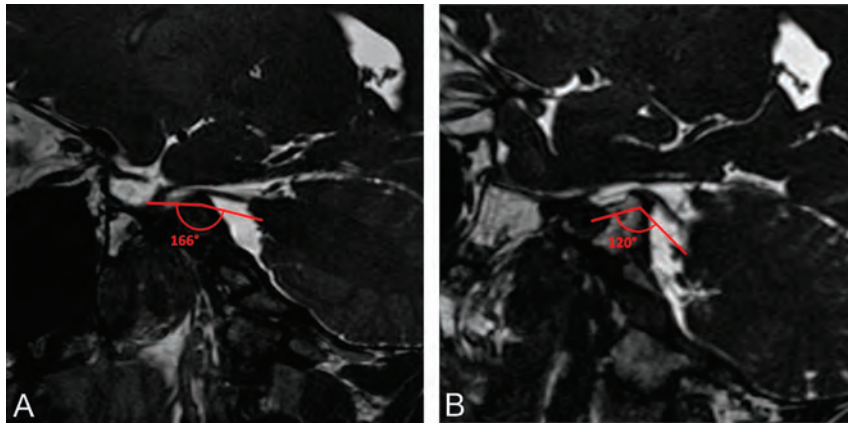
Sample measurements of the SATNaPT. Sagittal SSFP MR images show a normal angle of 166° (A) and a decreased angle of 120° (B). The angle measurements are shown below the nerves to avoid obscuring the anatomy.
